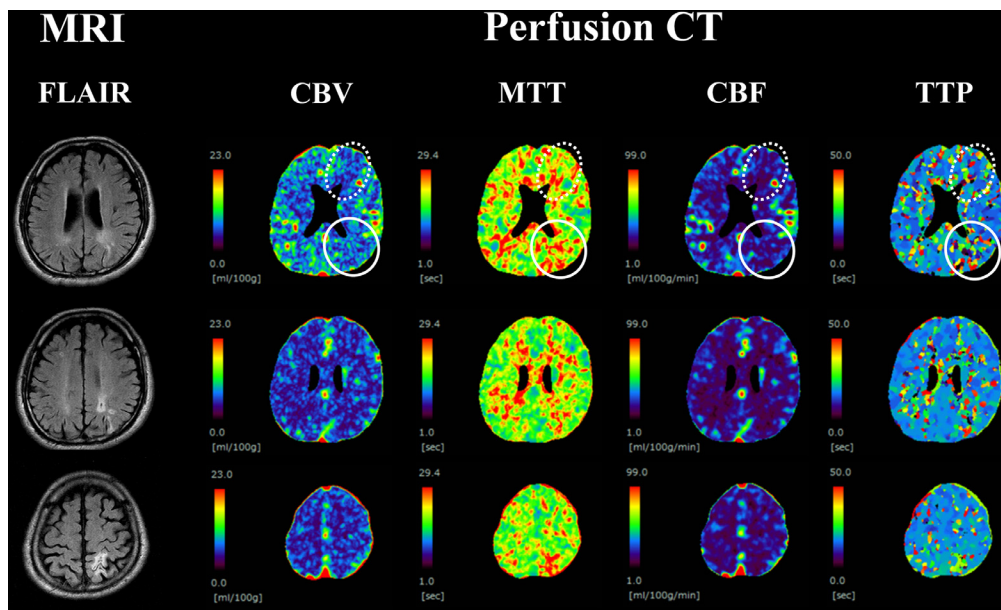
At the 4-month follow-up, perfusion computed tomography demonstrated decreased cerebral blood volume (CBV) and flow (CBF) and delayed mean transit time (MTT) and time-to-peak (TTP) over a wider area than the areas of infarction on FLAIR imaging. The dotted white circles indicate the watershed area between the anterior cerebral and middle cerebral arteries; the solid white circles indicate the watershed area between the middle cerebral and posterior cerebral arteries.
